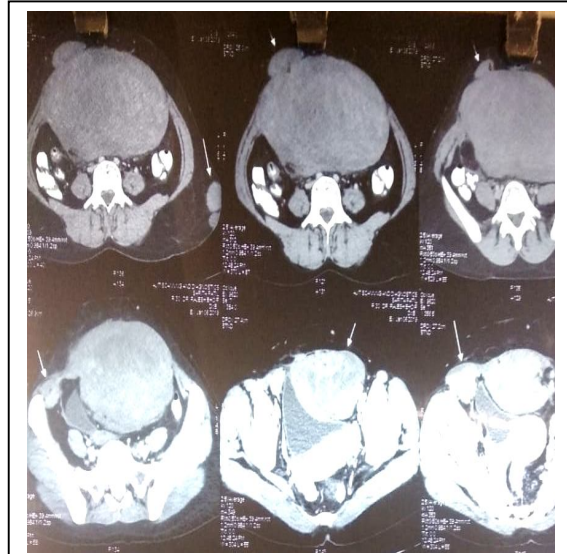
CT image showing the lump – coronal and sagittal sections
